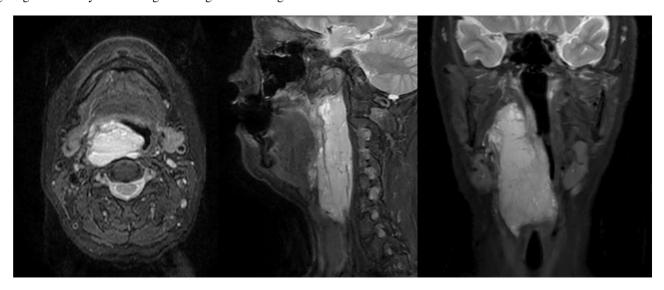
Fat-suppressed T2-weigted MR images demonstrate a longitudinal lobulated and septated mass with high signal intensity on the posterior pharyngeal wall. The calculated volume of the mass was $85.5 \pm 2.7 \text{ cm}^3$.
